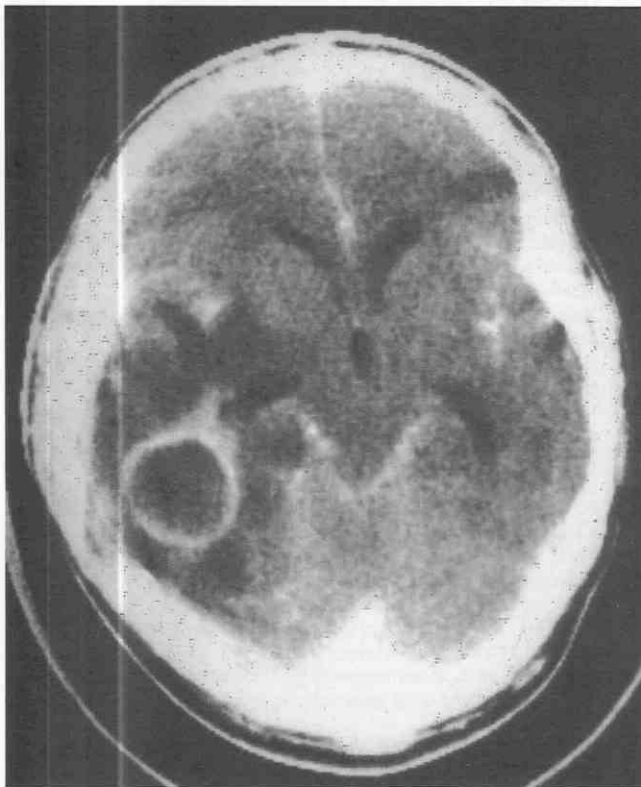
Abscess secondary to right temporal bone fracture. Contrast-enhanced CT scan shows ring enhancing abscess caused by *Staphylococcus* in the right temporal lobe.
